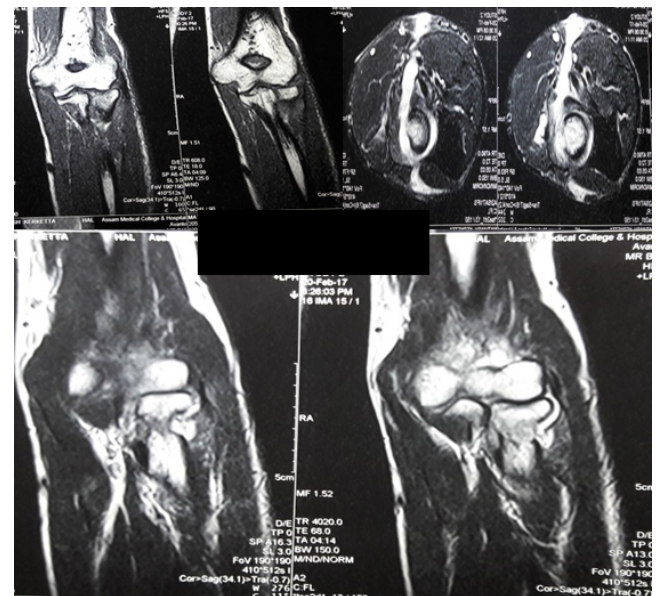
Magnetic resonance imaging showing involvement of radial head without involving distal humerus and proximal ulna.
